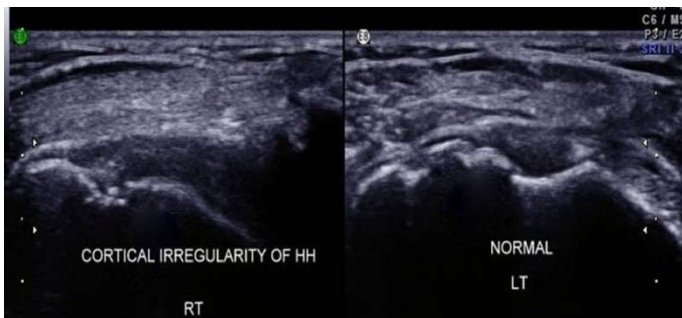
Bony Irregularity of the Humeral Head Which Was Occult On Radiograph
